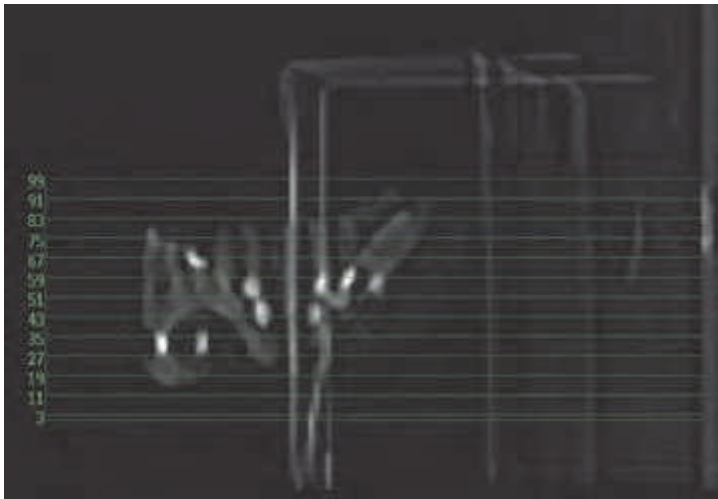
Profil scout-view of temporary prosthesis in its stand. Same acquisition volume as patient CT scan.
